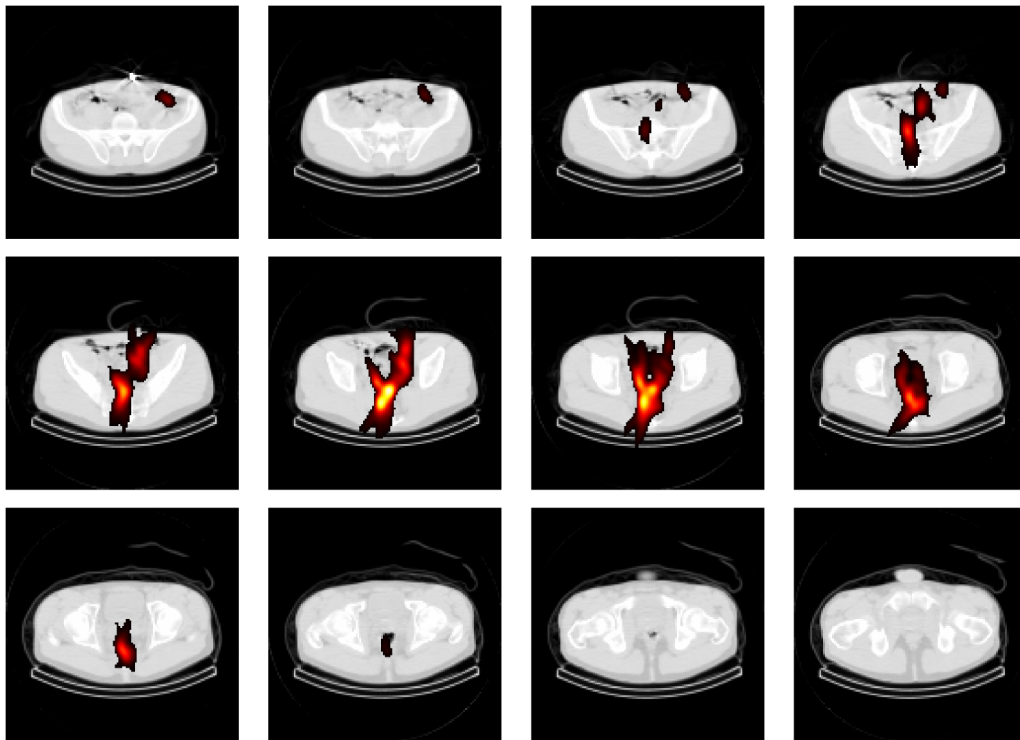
Processed SPECT images by transverse slices. Images proceeding from the upper left to the lower right proceed inferiorly (toward the feet). The selected images are spaced roughly 10 cm apart, with each image representing a 3.45-mm-thick slice. For anatomic reference, the hip bones are clearly visible in the upper-left plots.
